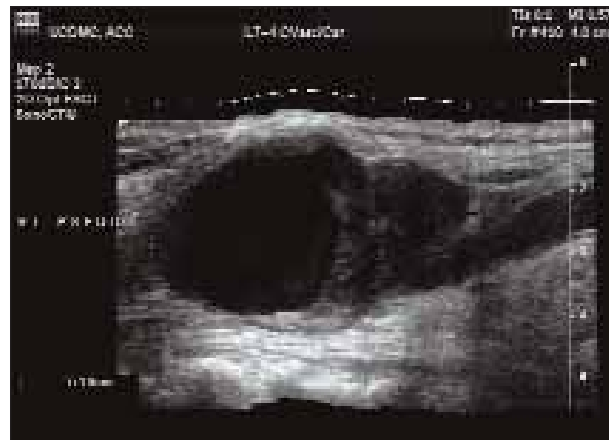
Duplex ultrasound evaluation of a pseudoaneurysm of the carotid artery 9 months after carotid endarterectomy with Dacron patch closure.
